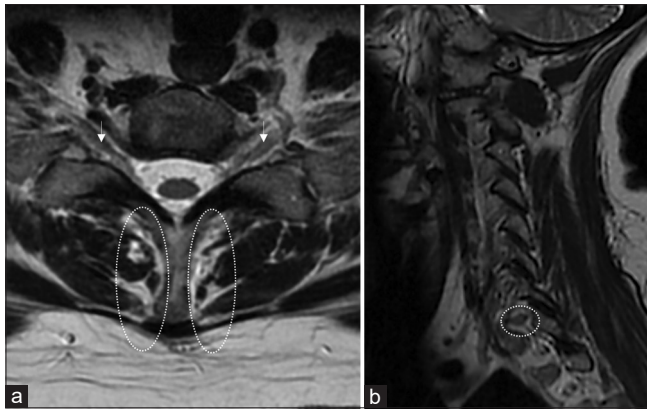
Plain T2W MRI cervical spine (axial section, a) and upper thoracic level (sagittal section, b) showing hypertrophic bilateral nerve roots at the level of C7-T1 in the axial plane (arrows). Right parasagittal MRI showing right-sided hypertrophic nerve root in the neural foramen at the same level (dotted circle). Paraspinal thoracic muscle atrophy and fatty infiltration (white fat) are also shown (dotted oval)
